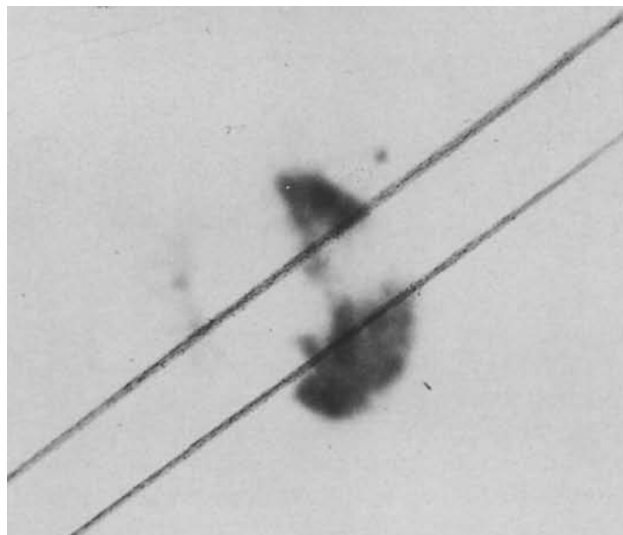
Example perfusion SPECT image with an oblique opposed pair of treatment fields. This is one of the first functional-guided RT plans applied to limit dose to functional lung. Note: Image from “The utility of SPECT lung perfusion scans in minimizing and assessing the physiologic consequences of thoracic irradiation” by L.B. Marks et al., *International Journal of Radiation Oncology Biology Physics*, 1993, 26(4), pp. 659-668.
